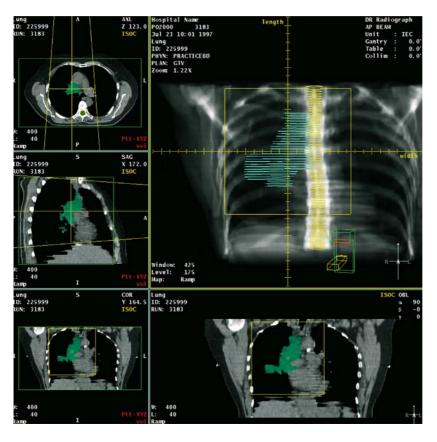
Gross tumor volume (GTV) contours shown in *green* and spinal cord contours in *yellow* are overlaid on the coronal DRR (*upper right*), and on axial, sagittal, and coronal CT slices. The projection of the field borders on the patient is shown in *yellow* in each panel
